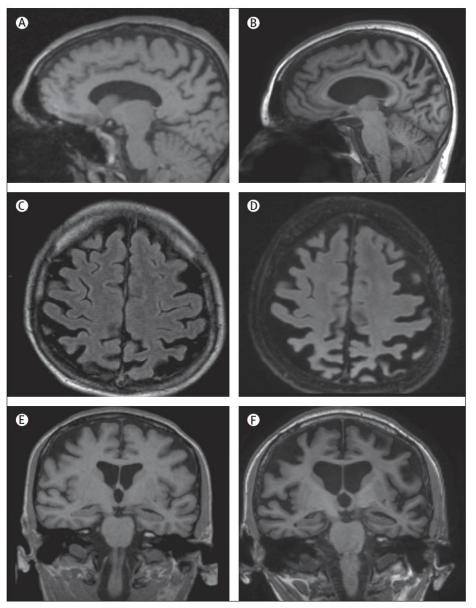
MRI at baseline (left column) and at 2 years of follow-up (right column) in a woman aged 52 years with Alzheimer's disease and APOE $\epsilon 3/\epsilon 3$ genotype
